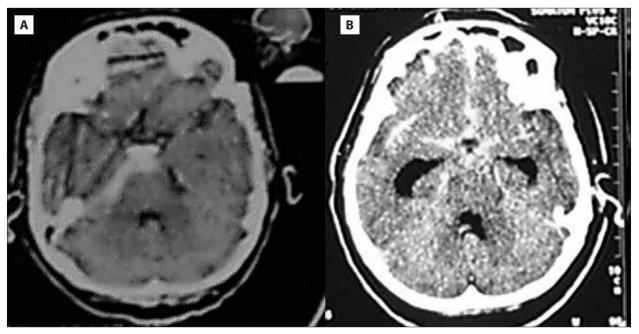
CT of patients with PNSAH (A) and NPNSAH (B)
